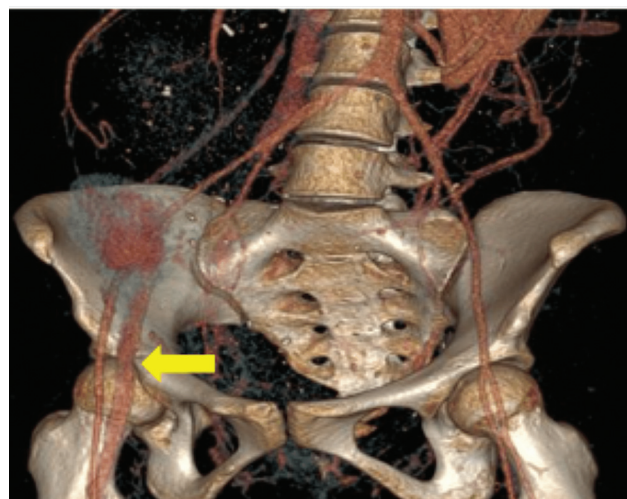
Contrast-enhanced computed tomography abdomen (CECT-ABD) (venous phase) volume rendering image displaying nonvisualization of left common iliac, external iliac, and common femoral veins and normal appearing veins on the contralateral side.
